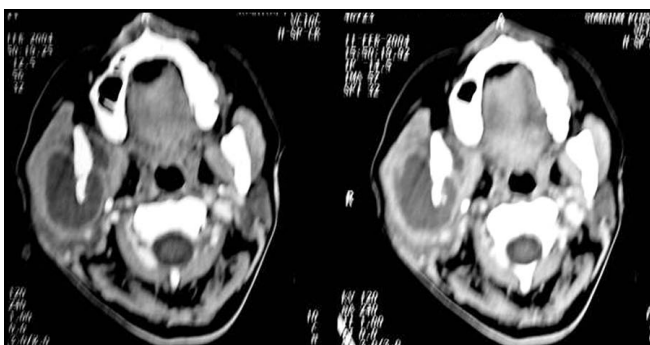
Axial CT showing hypodense peripherally enhancing lesion with erosion of bone (Ref. Fig. No. 18.5B)
